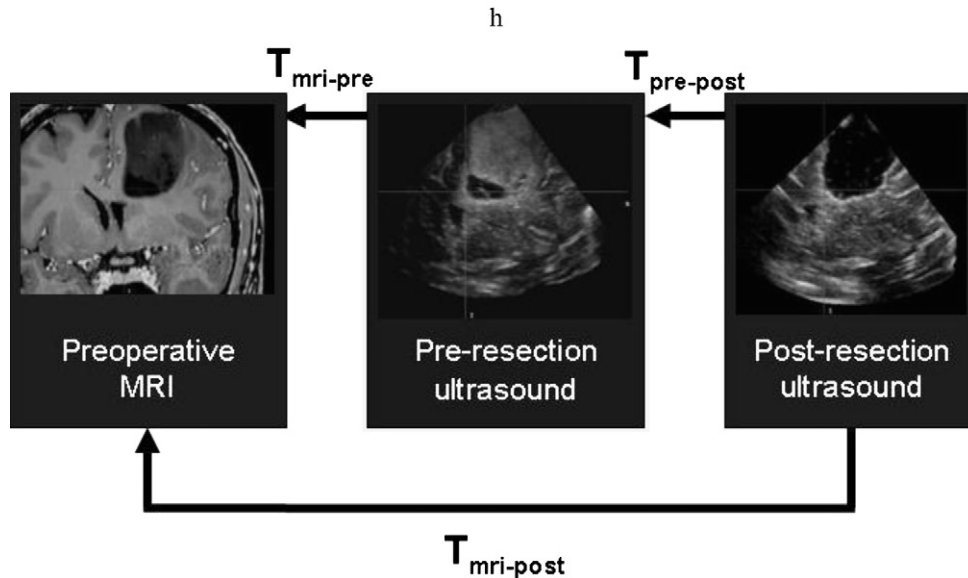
The varying transformations ( $T$ ) between the preoperative MR images and intraoperative ultrasound images. The transformation can be nonlinear or rigid. The subscript should be read from right to left in the same manner as matrix multiplications are carried out.
